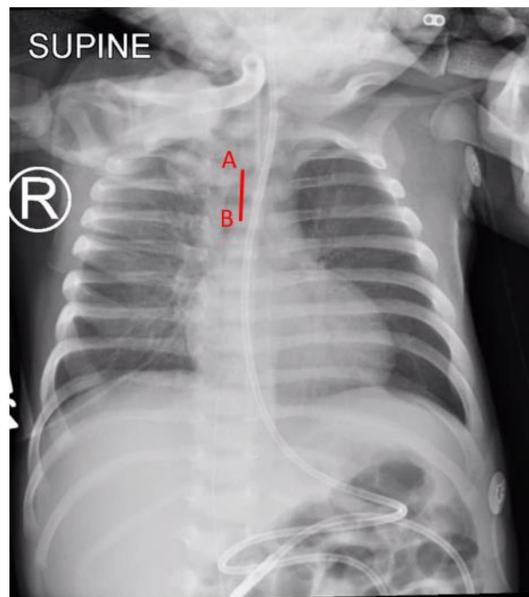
X-ray Measurement of Tracheostomy Tube Position
